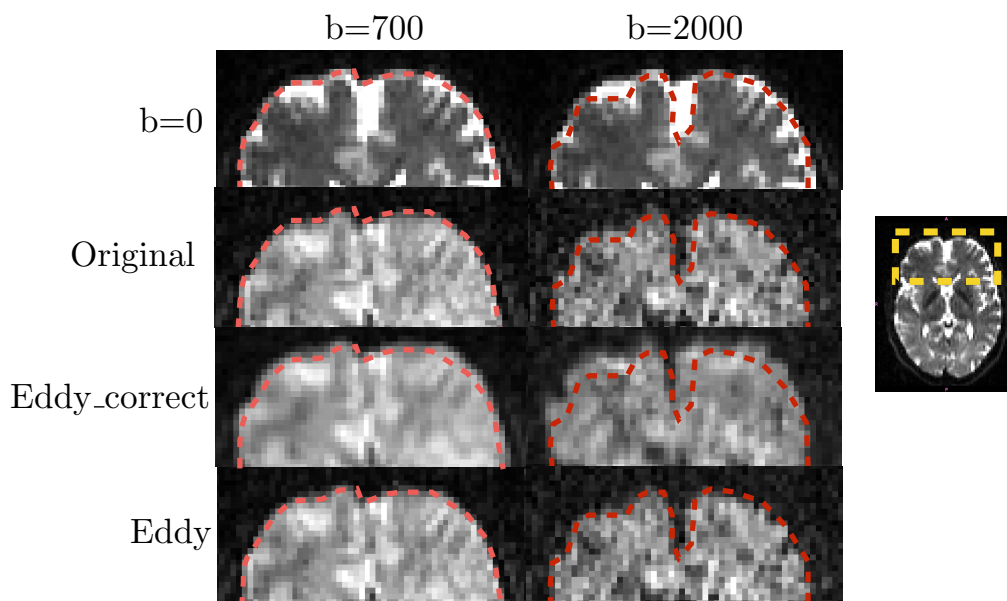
Correction errors on real data. Anterior portion of the brain in an axial slice is shown, corresponding to the yellow region on the inset image. An outline was drawn around the undistorted $b=0$ image, then superposed on a DWI. The boundaries of an undistorted DWI should align with this outline. Different outlines were drawn on the $b=0$ for use on the $b=700$ and $b=2000$ volumes, to account for the different amounts of CSF attenuation present.
